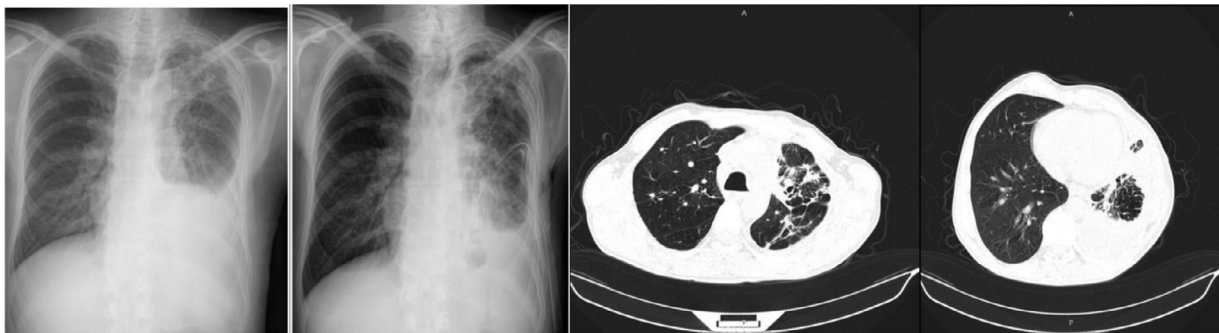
Fifth MSCT and chest radiography reveal a large malignant left pleural effusion
